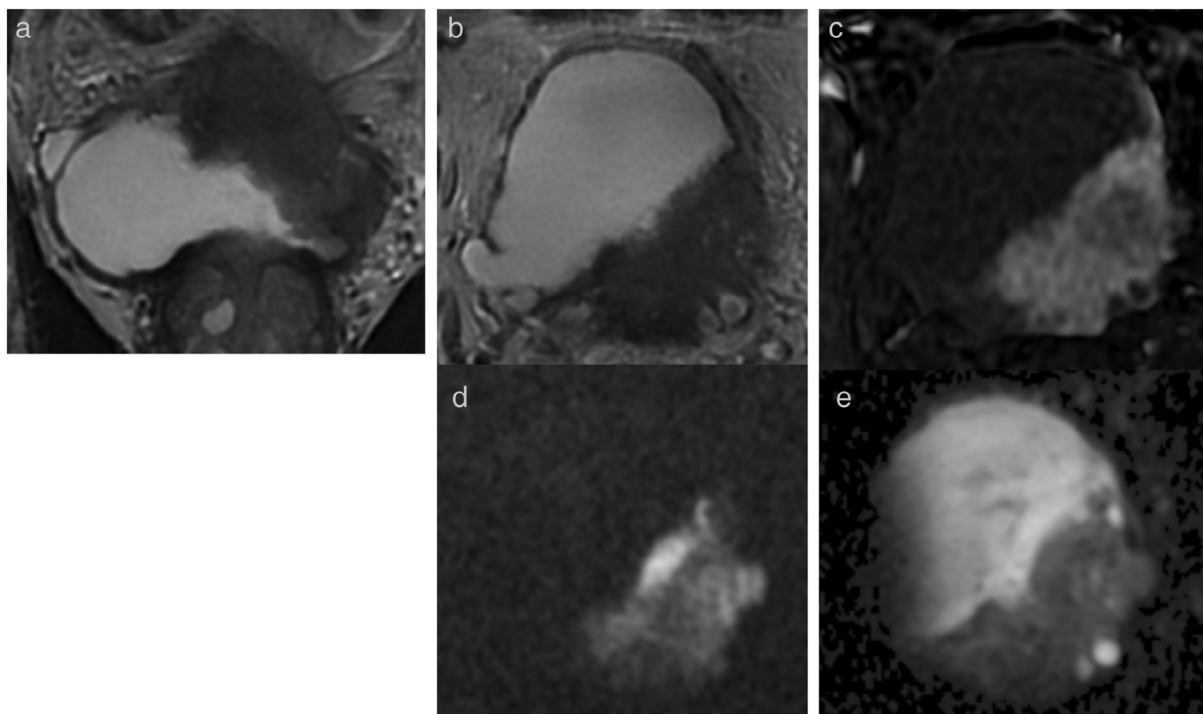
A 73-year-old male with positive ultrasound. (a,b) T₂W imaging (coronal, axial plane) shows a sessile mass >1 cm in size at the level of the posterosuperior bladder wall, with intermediate SI that extends through the muscularis propria, invading the perivesical fat tissue. T₂W imaging assigned as VIRADS category 5. (c) DCE imaging shows early and heterogeneous enhancement of the lesion, extending through the muscularis propria, invading the perivesical fat tissue. DCE assigned as VI-RADS category 5. (d,e) DWI (b = 2000) and ADC maps show a lesion with significant restricted diffusion, extending through the muscularis propria, invading the perivesical fat tissue. DWI assigned as VIRADS category 5. Overall VI-RADS score was 5.
